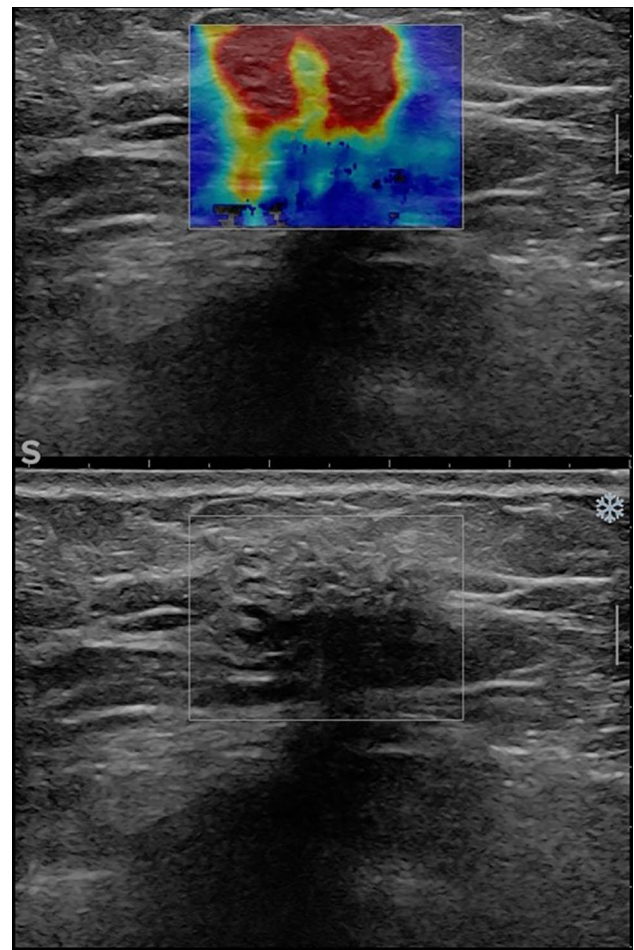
B-mode ultrasound shows a non-mass lesion with posterior acoustic shadowing. Ultra-fast SWE shows in the colorimetric map a significant increase in stiffness both contextual to the lesion and in the peripheral tissue, also supported by the numerical values of the ratio between kPa suspicious tissue/kPa healthy tissue (kPa ratio 14.96). The lesion resulted to be a non-special type invasive breast cancer
